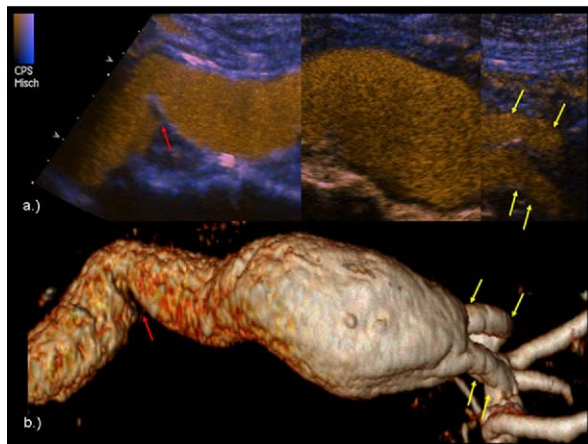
Intraoperative visualization of an infrarenal aortic aneurysm using contrast enhanced ultrasonography (a) in comparison to three-dimensional reconstruction of the magnetic resonance imaging (MRI) data obtained during MR angiography (b). The red arrow shows the infrarenal aortic kinking and the yellow arrows demonstrate the distal landing zone at level of the common iliac arteries.
